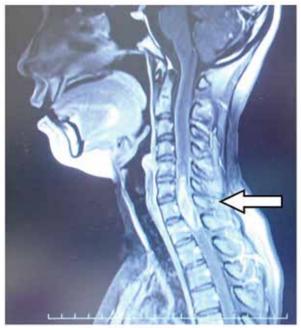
Sagittal T1-weighted magnetic resonance image of the patient's cervical cord showing an intramedullary mass at the C6–T1 level (arrow).
